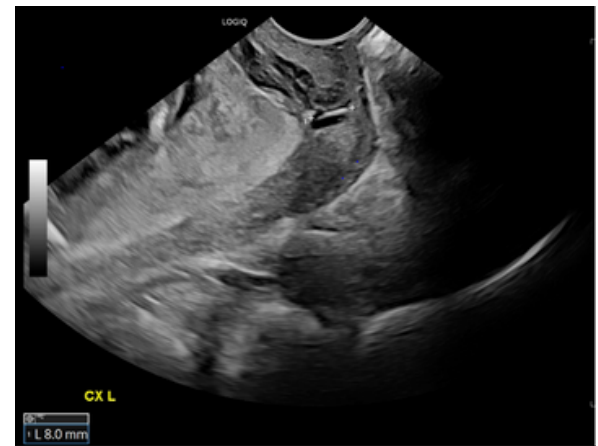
Ultrasound at 16+3 demonstrating a shortened cervix and placenta covering the internal os
